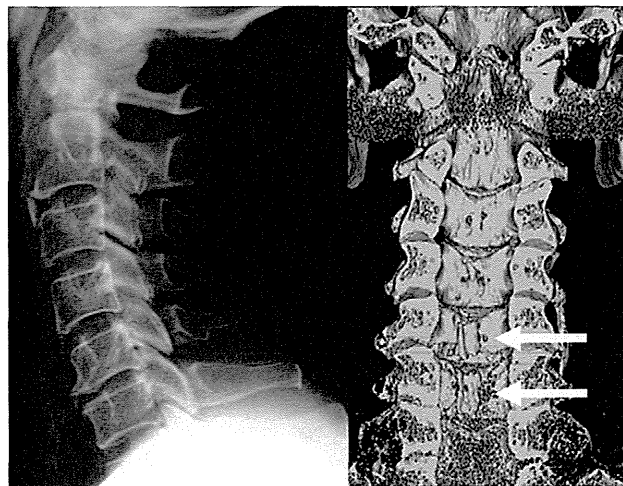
Images of the cervical spine of a 72-year-old male patient. (Left) Lateral radiograph. (Right) Three-dimensional computed tomography image. The arrows show small ossified lesions at C5 and C6.
